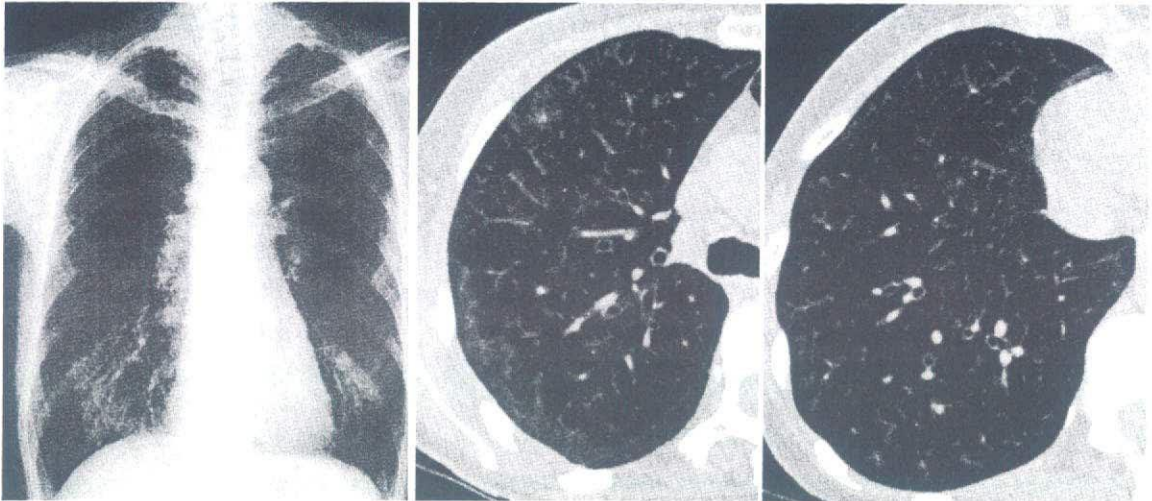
Chest radiograph and CT scan on admission of Case 2 showing diffuse panbronchiolitis-like centrilobular small nodules and ground-glass appearance.
